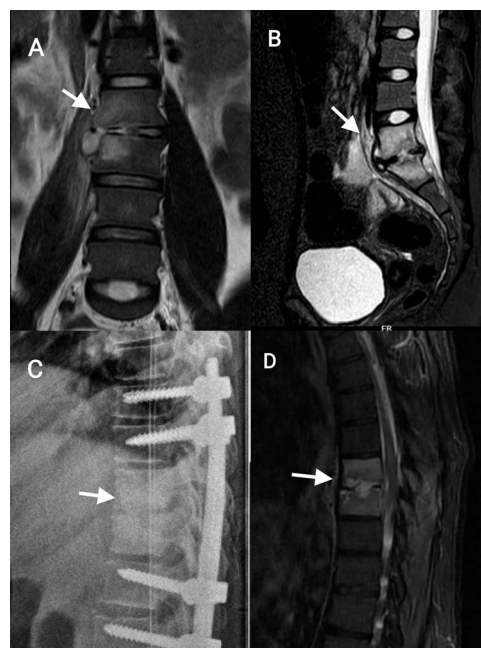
(A) Coronal short tau inversion recovery (STIR) sequence on MRI shows spondylodiscitis at L2–L3 level. (B) Sagittal STIR spondylodiscitis sequence on MRI shows at L5–S1 level along with a paravertebral abscess. (C) Lateral X-ray of the spine shows spondylodiscitis at D10–D11 level with screws in the vertebra above and below. (D) Sagittal STIR spondylodiscitis sequence on MRI shows at D8–D9 level.
